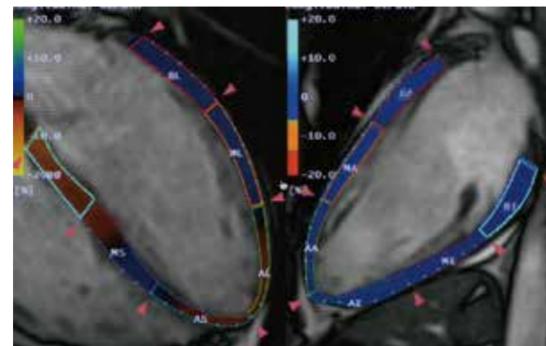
Myocardial strain analysis using cine MRI.
